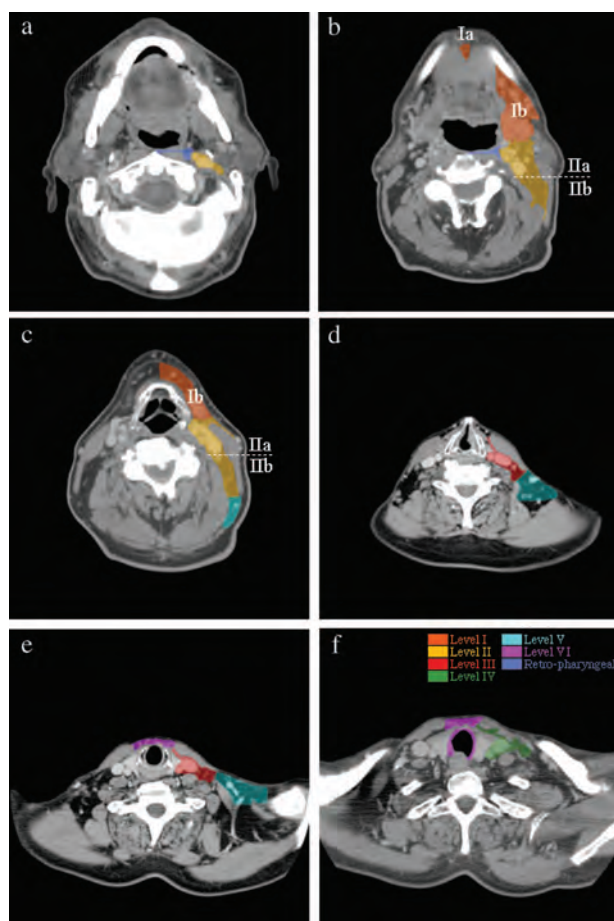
Three-dimensional delineation of neck nodes at different levels for head-and-neck squamous-cell carcinoma (SSC). Computed tomographic imaging of a patient with a T1N0M0 glottic SCC (see tumor in panel d). The examination was performed on a dual-detector spiral CT (Elsint Twin, Haifa, Israel) using a slice thickness of 2.7 mm, a reconstruction interval of 2 mm, and a pitch of 0.7 mm. Contrast medium was injected intravenously at a rate of 2 ml/s to a total of 100 ml. Sections were taken at the level of the bottom edge of C1 (panel a), the upper edge of C3 (panel b), mid-C4 (panel c), the bottom edge of C6 (panel d), the bottom edge of C7 (panel e), and mid-D1 (panel f). Neck nodes at each level were drawn on the CT slice using the radiological boundaries published by Grégoire *et al.* (2003c).
